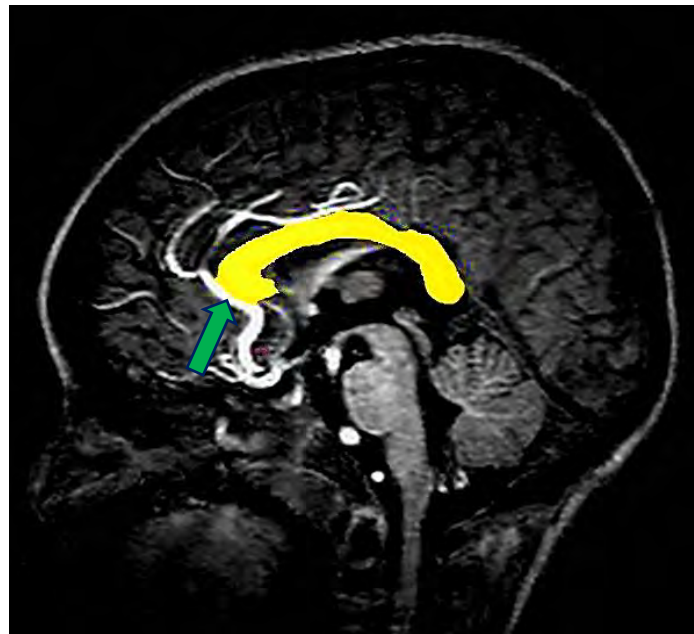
Sagittal view of an MRI scan showing the corpus callosum in yellow
